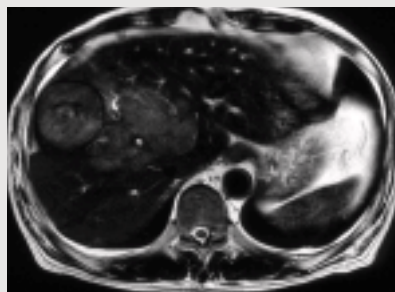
2 T2-weighted images
